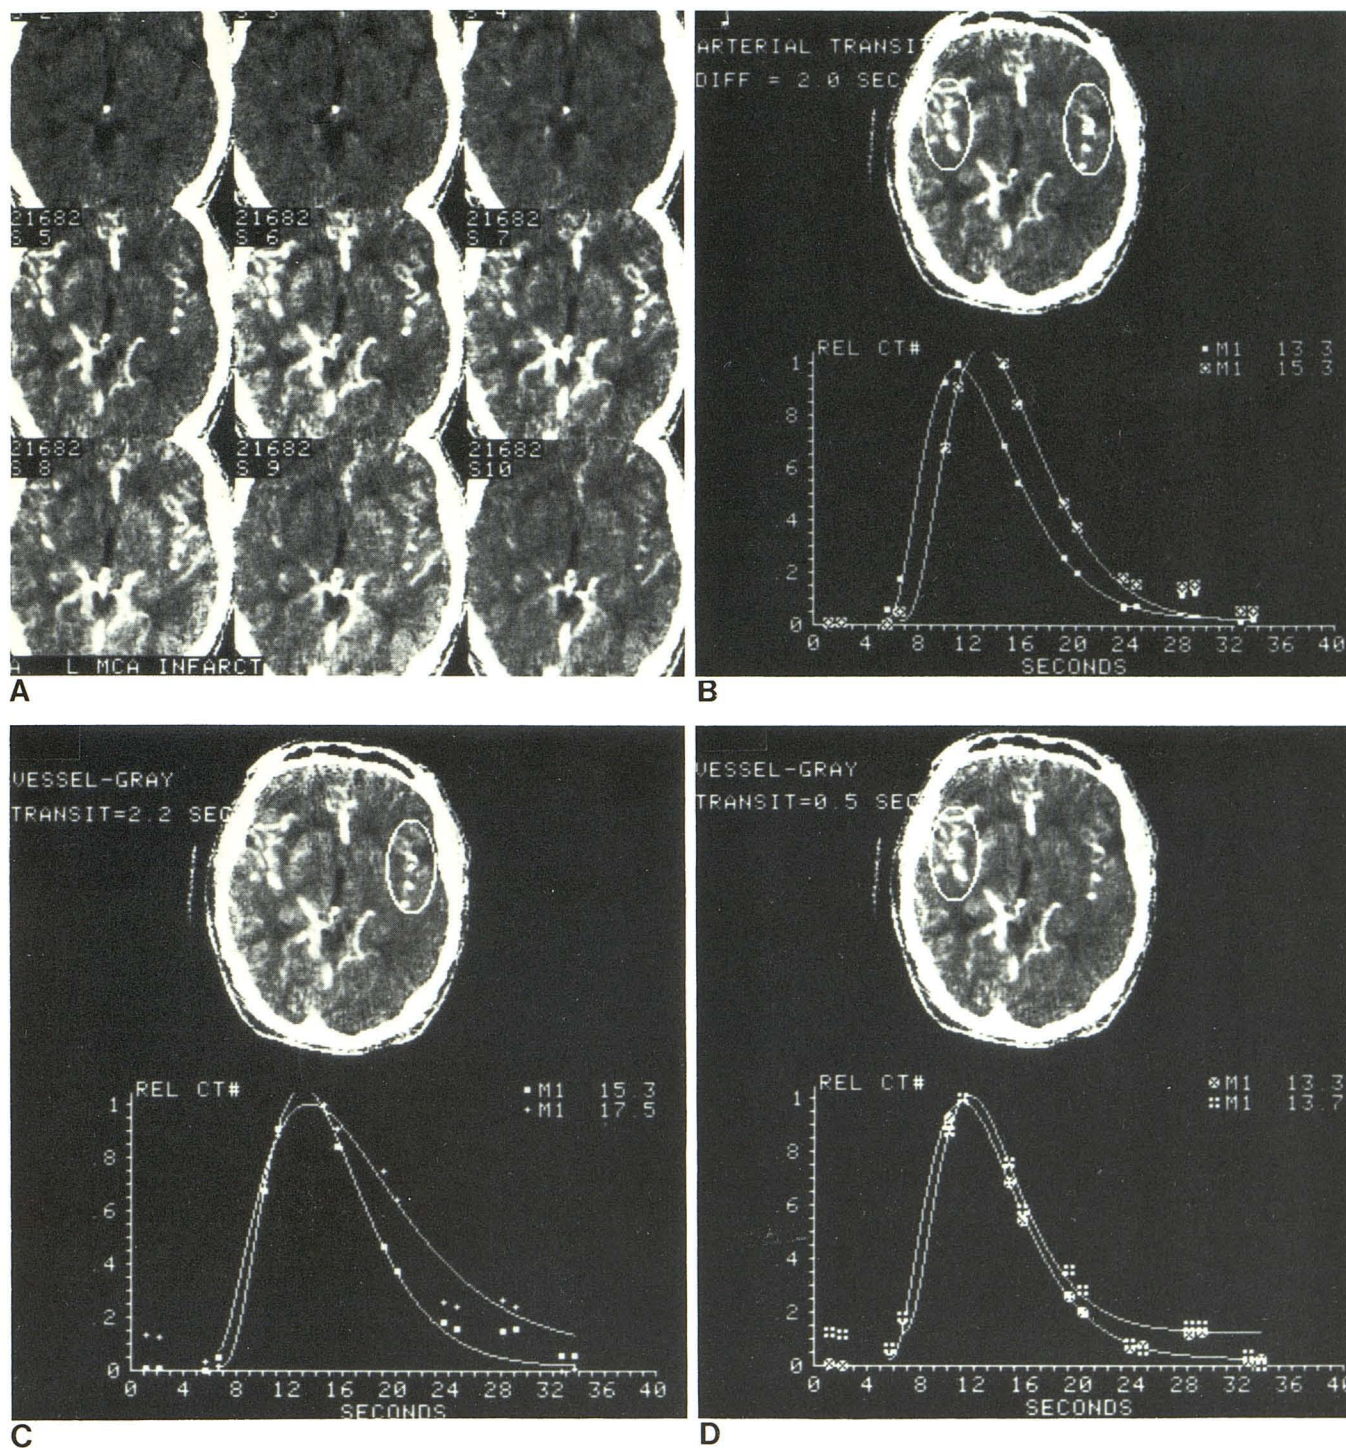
Case 3, 56-year-old woman who had acute left middle cerebral artery stroke 3 days before. Pre- and postcontrast static CT scans were normal. A, Rapid sequence scan. Relatively less filling on left. B, Arterial transit difference is 2.0 sec (■ = right, ⊞ = left). Corrected mean transit time
